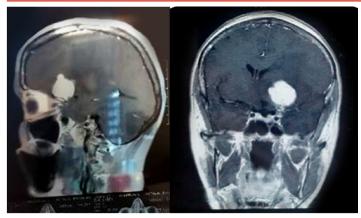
MRI, sagittal and coronary sections revealing an irregular tumor compressing the front horn of the left ventricle, associated with perilesional edema.
